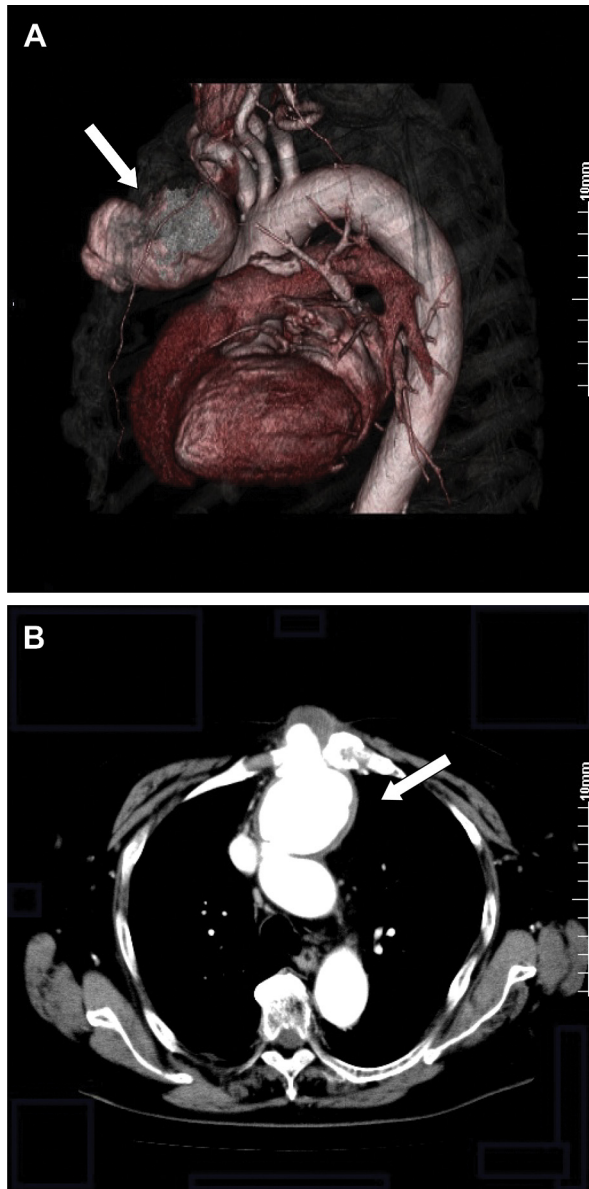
An ascending aortic pseudoaneurysm with an extrathoracic component eroding the sternum (*arrows*) is shown in a preoperative (A) volume-rendered computed tomography (CT) angiogram and in an (B) axial CT image.
